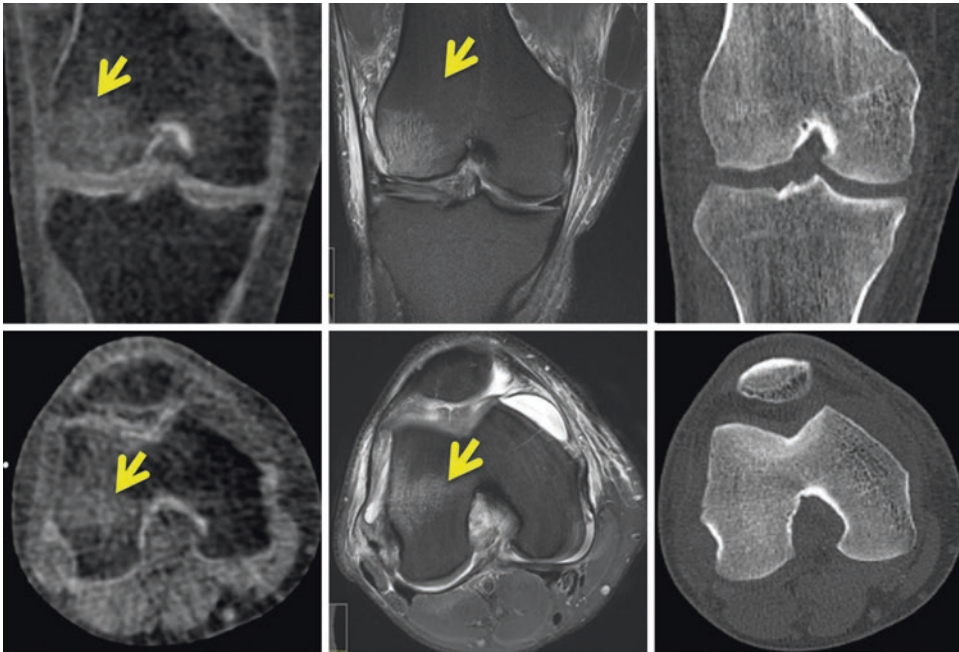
Coronal (top row) and axial (bottom row) images of a patient's knee subsequent to a traumatic injury to his knee. The MRI images (center column) demonstrate signal within the bone marrow (arrows), which corresponds to bone edema secondary to trauma. The conventional CT images (right column) do not demonstrate any pathology;
